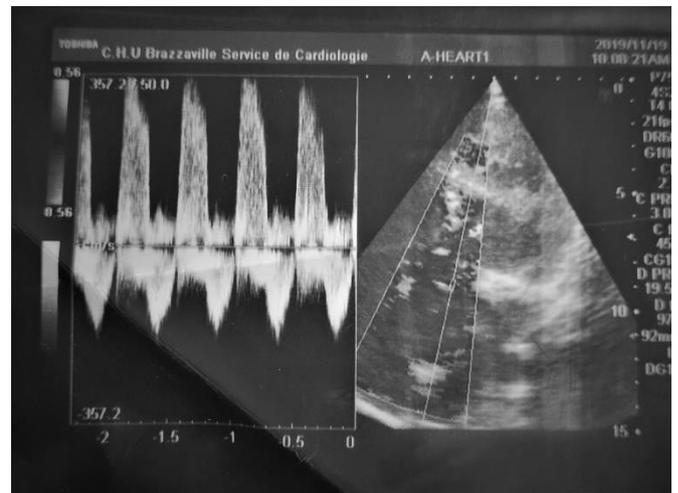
Doppler Echocardiography shows severe aortic insufficiency.
